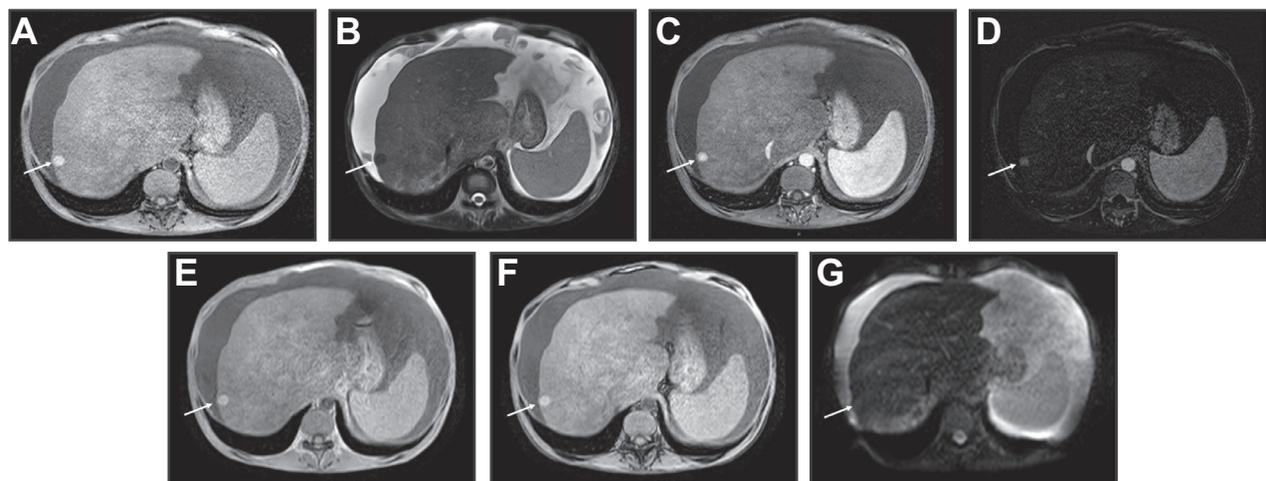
Benign lesion without washout appearance in 36-year-old woman with primary Budd-Chiari syndrome due to myeloproliferative neoplasm and anti-phospholipid syndrome. (A) Precontrast T1-w images showed a 15 mm hyperintense lesion in the right liver. (B) This lesion was hypointense on T2-w images. (C-F) Extracellular gadolinium-based enhanced fat-suppressed T1-weighted GE MR images showed arterial phase hyperenhancement (C), confirmed by image subtraction (D), hyperintensity on portal venous phase (E) and hyperintensity on delayed phase (F). (G) The lesion was not seen on diffusion-weighted images. Serum alpha-fetoprotein was 5 ng/L. The patient was followed up for 12 months and remained hepatocellular carcinoma-free.
